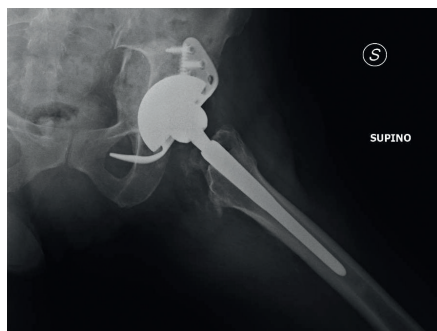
Preoperative X-ray: acetabular fracture is observed.
